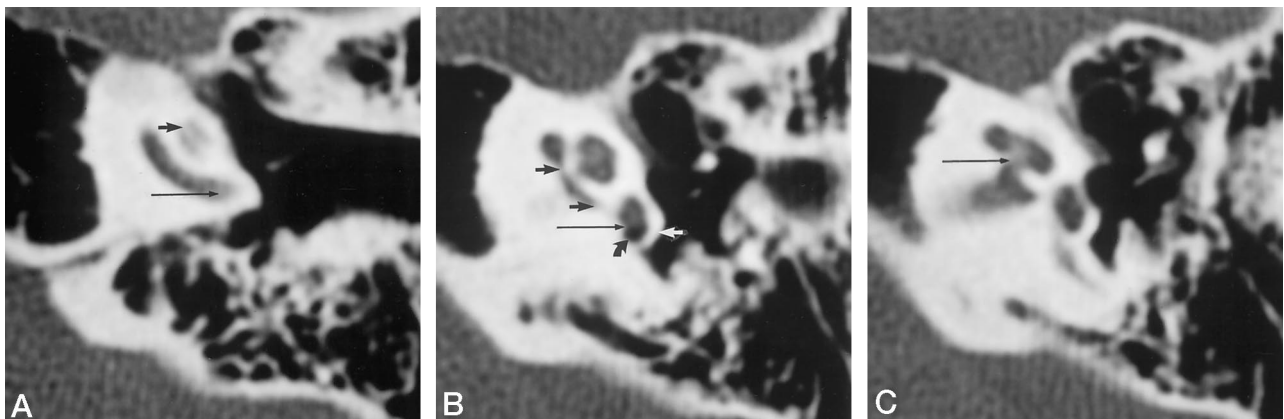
Normal left cochlea shown on first, third, and fourth of five consecutive high-resolution CT sections (1.5-mm thick every 1 mm), from inferior to superior, obtained with an edge-enhancement algorithm at a $+30^\circ$ plane.
